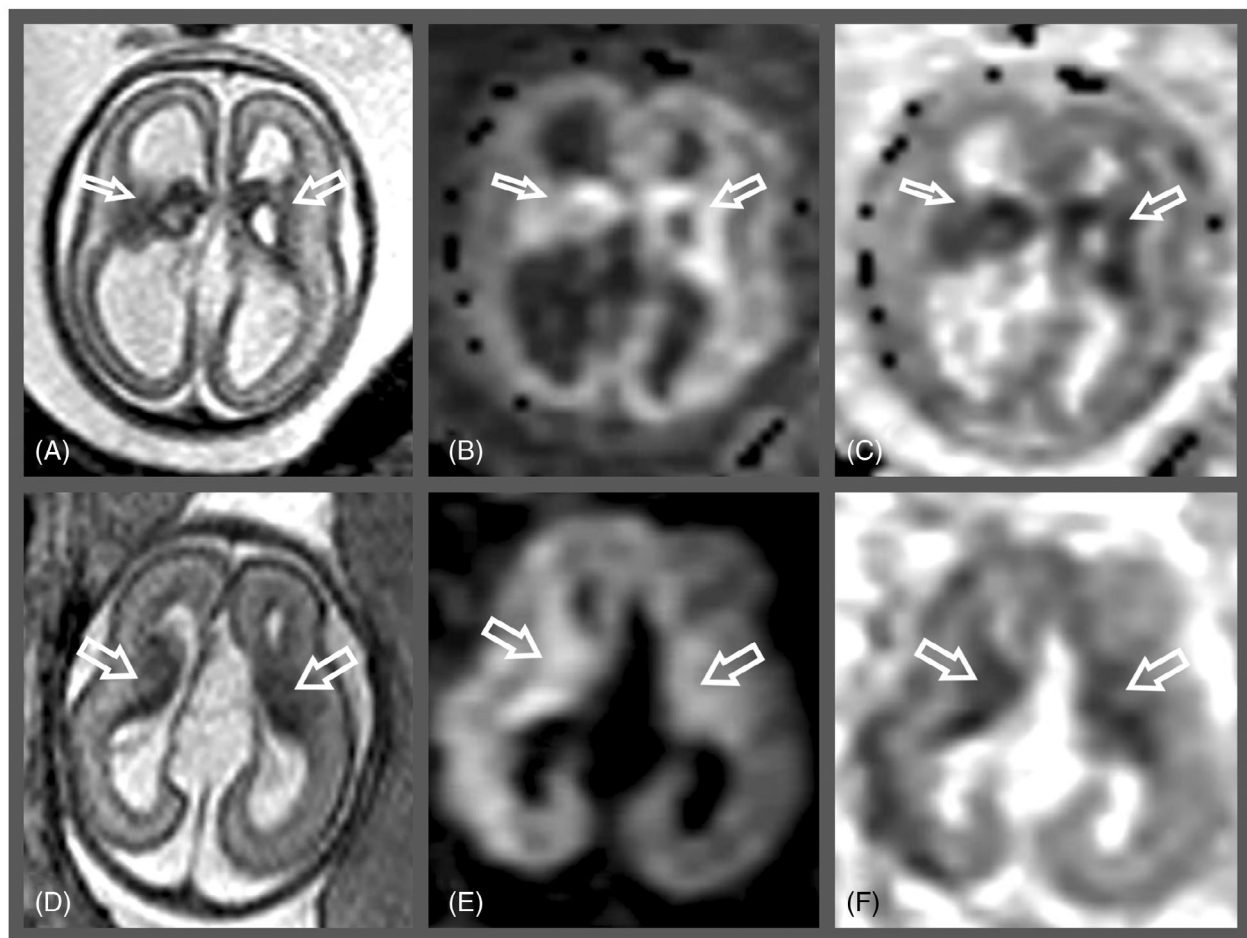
Ganglionic eminence abnormalities: (A–C) Cavitations in a 21 GW fetus: (A) axial T2-weighted images and (B) diffusion-weighted image with (C) corresponding ADC map shows bilateral cavitations in the ganglionic eminences surrounded by disorganized, nodular appearance of the surrounding germinal matrix showing restricted diffusion (arrows) due to the increased cellularity. (D, E) Fetus at 21 GW with corpus callosum dysgenesis and an interhemispheric cyst: (D) axial T2-weighted image, (E) diffusion-weighted image, and (F) corresponding ADC map shows bilateral enlargement of the ganglionic eminences, again with restricted diffusion (arrows)
